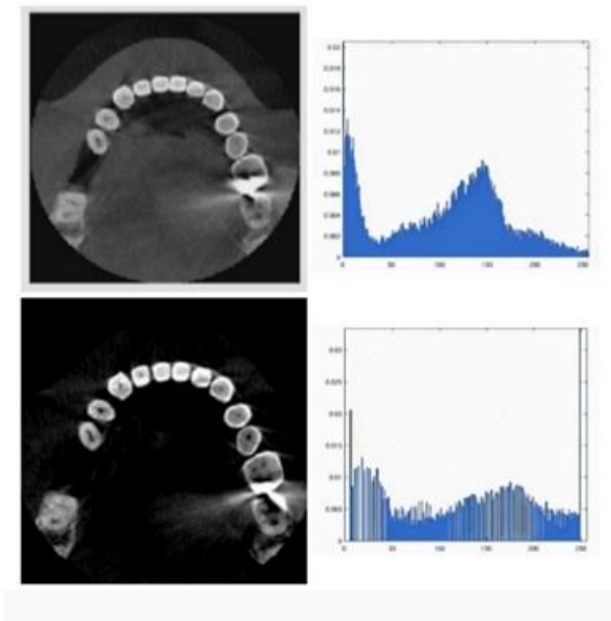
View of histogram function for CBCT image, (upper image is the original histogram before equalization and the other one is the equalized one.)
